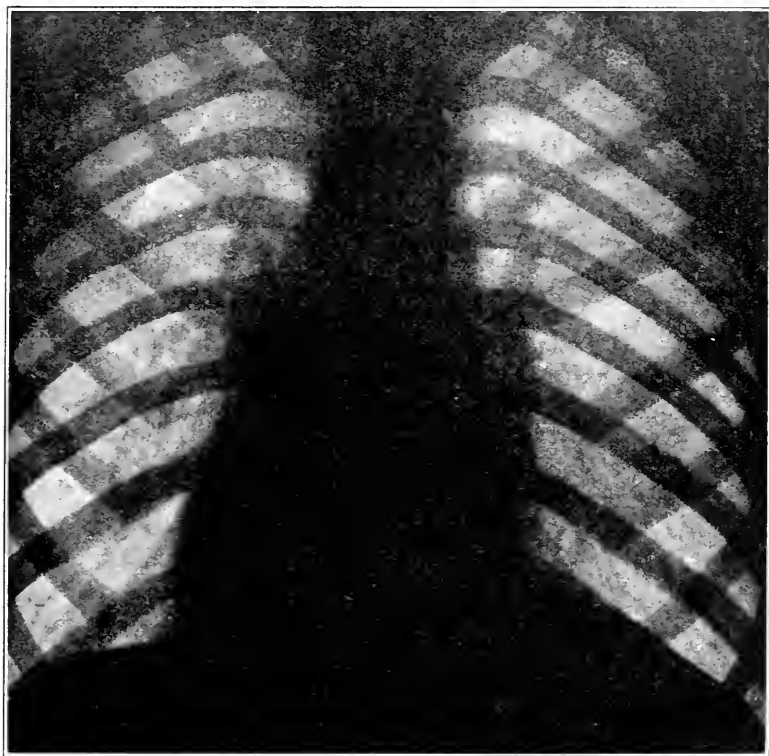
Radiograph—the chest of the hyposthenic habitus.
